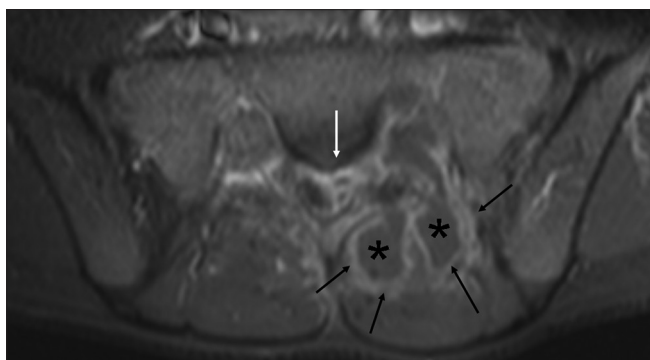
Axial, T1-weighted MR images with Gadolinium injection showing two necrotic collections (asterisks) within the left paraspinal muscles with thick enhancing walls (black arrows) extending to the spinal canal in form of a septated collection (white arrow)
